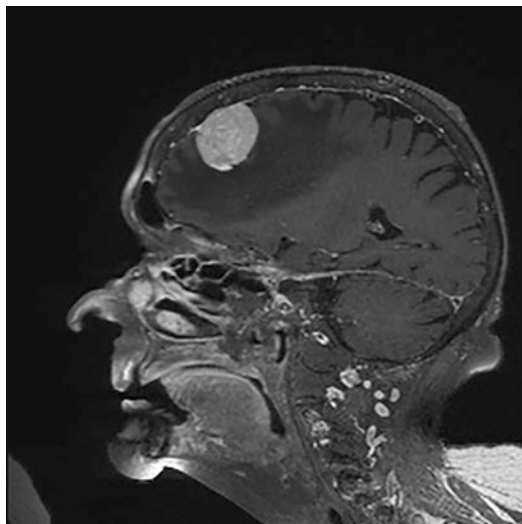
MRI of an extra-axial meningioma. This secretory meningioma has significant perilesional edema
